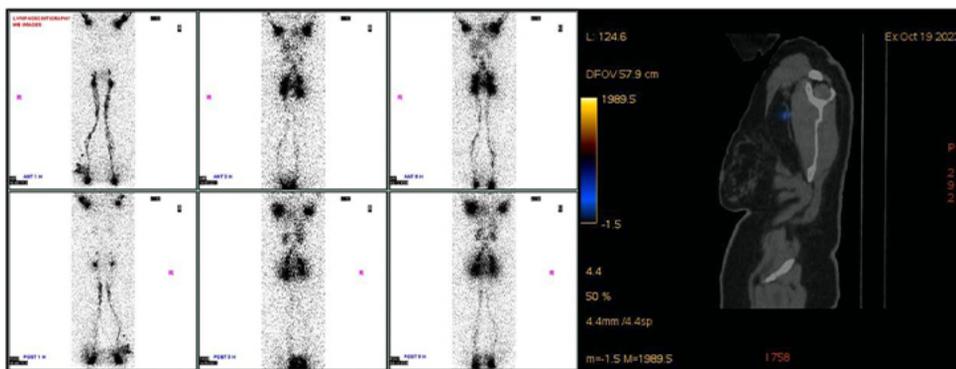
Lymphoscintigraphy shows normal lymphatic flow with normal appearance of thoracic duct.
